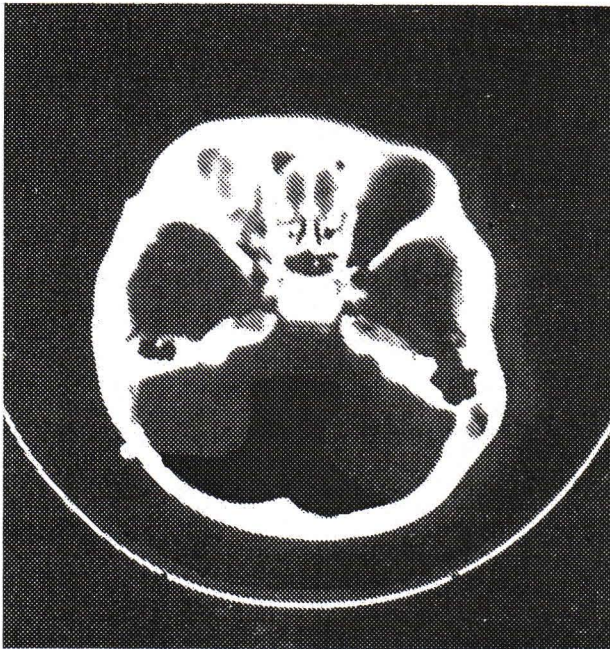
CT brain showed Dandy - Walker anomaly.
